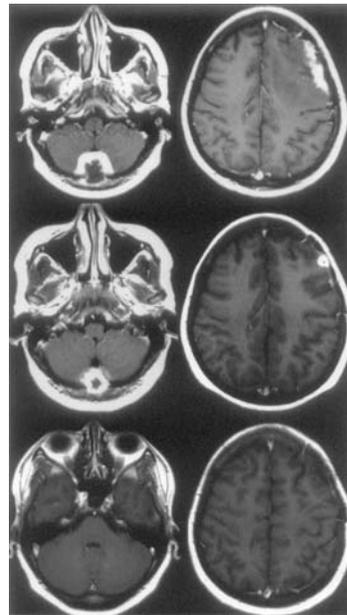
Follow-up MRI scan after resection of the left frontal lesion: T1 gadolinium enhanced images, 24 hours after surgical decompression (top row), 4 months (middle row) and 18 months (bottom row) follow-up showing resolution of the tuberculomas under an INH, RMP, and EMB regimen. Interestingly, despite the invasive growth and dural and bone destruction no complications due to erosion of the sinus such as haemorrhage or thrombosis had occurred
